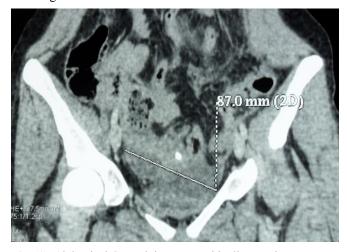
Abdominal CT: Pelvic masses with gliomatosis
